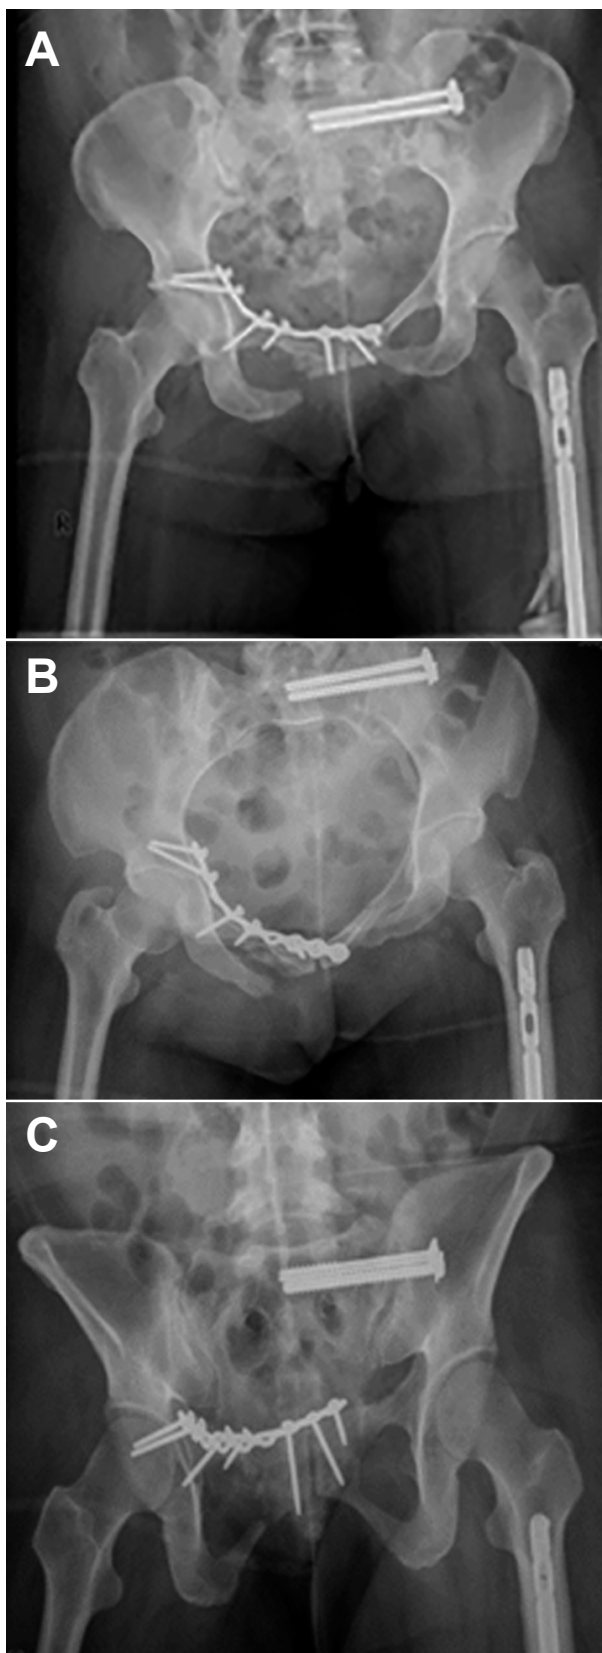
Radiographs of pelvis showing iliosacral screws and anterior pelvic fixation performed at an outside facility (A); inlet (B) and outlet (C) views.
